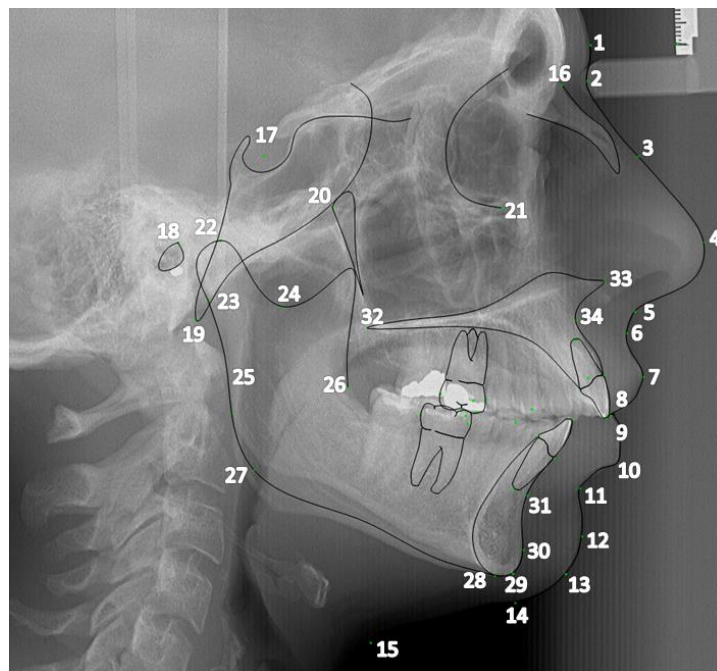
Soft and hard tissue landmarks digitized on a lateral cephalometric radiograph.
